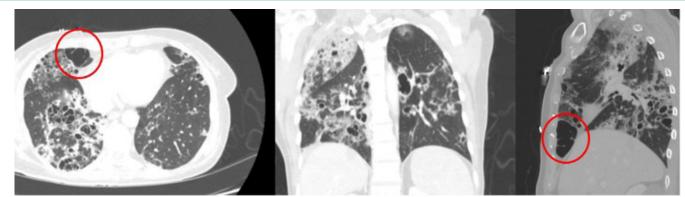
Pre-admission chest CT scan showing diffuse cystic lung disease with large right middle lobe cyst as the suspected site of rupture.
